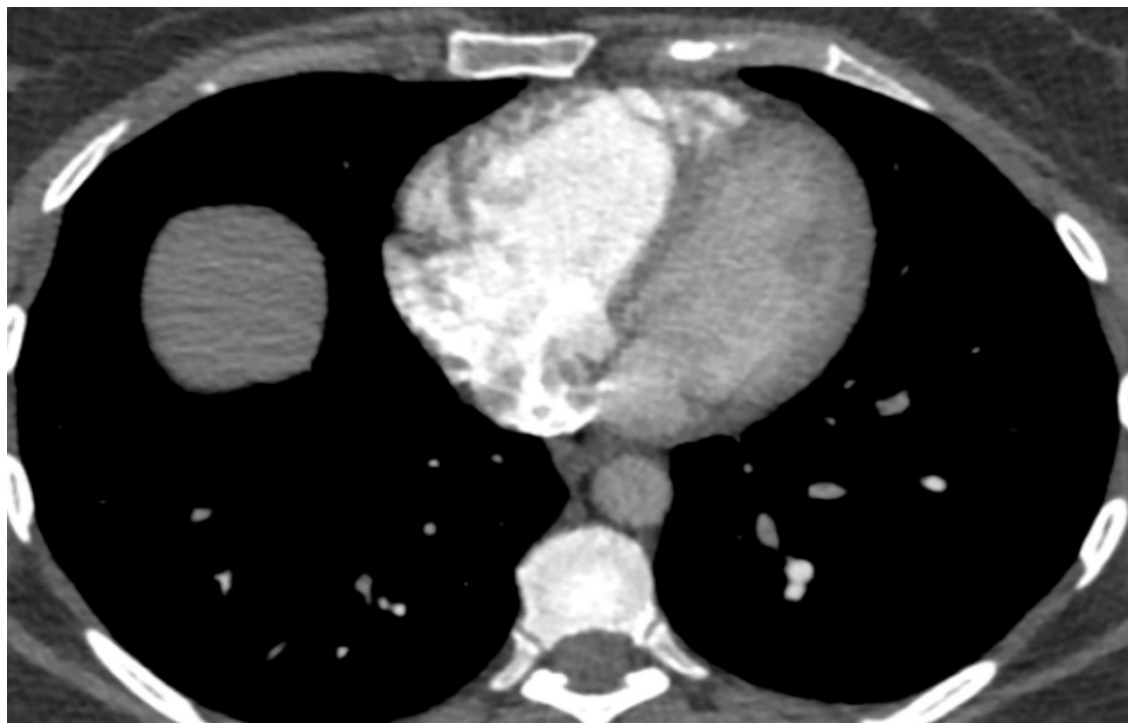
Positive CT angiography for acute PE. Signs of RV dysfunction; note increased RV dimensions (RV/LV ratio >1) and ventricular septum bowing leftward.
